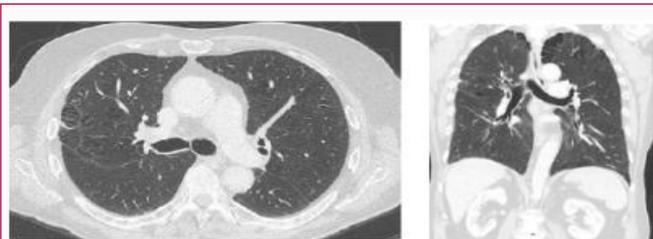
Chest computed tomography, 50 months after surgical resection, with no recurrence of cancer.
